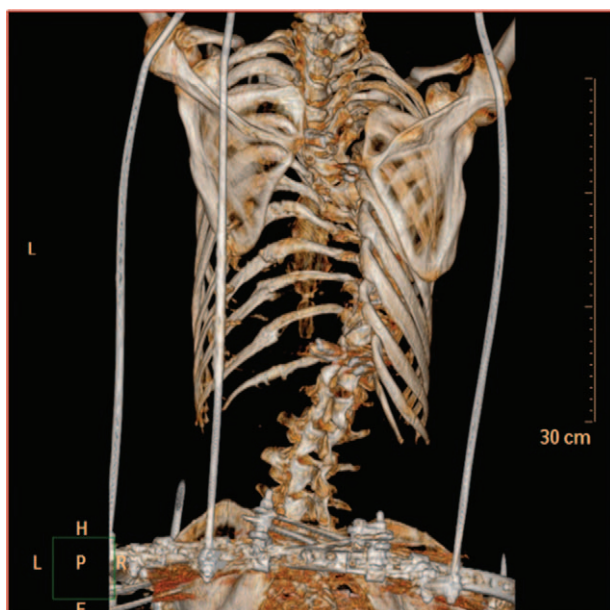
3D CT images of fusion of the broken rib ends.
